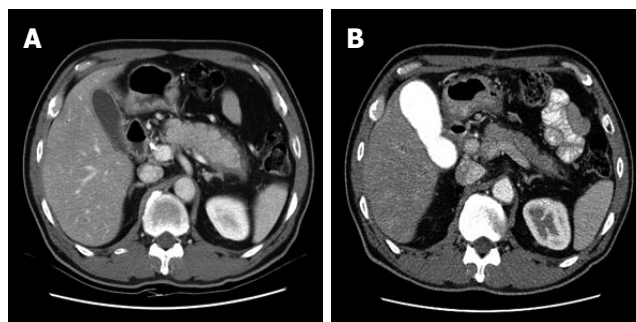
Abdominal CT findings. A: Diffusely enlarged pancreas without any calcification or stones in a 59 year-old man. A capsule-like low-density rim can also be seen around the pancreas; B: After steroid therapy, the pancreas returned to its normal size and the rim disappeared.
